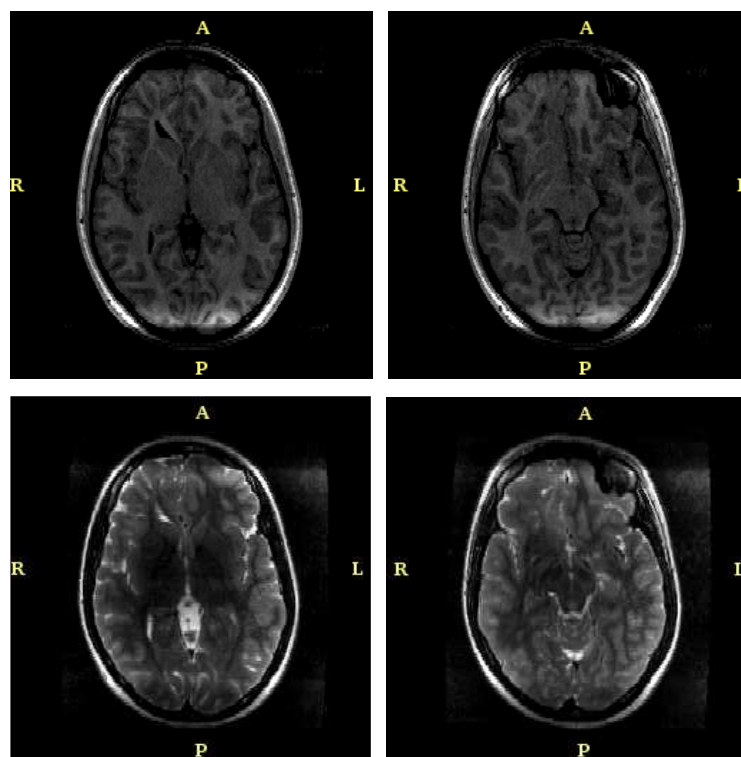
Patient Example 1 - Intensity Inhomogeneity Correction. Top Row: Intensity Corrected T1-weighted volume. Bottom Row: Intensity Corrected T2-weighted volume.
